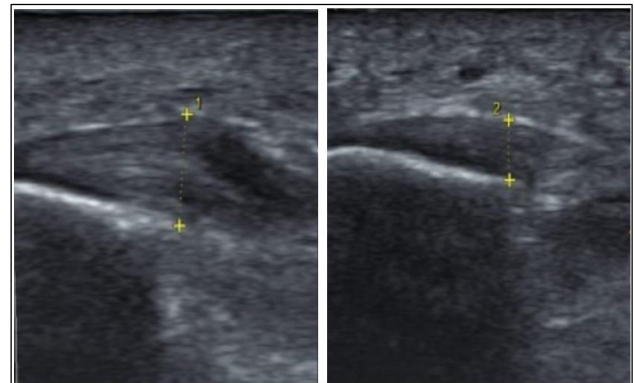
Pre-injection and post-injection plantar fascia thickness as seen under ultrasonography.
